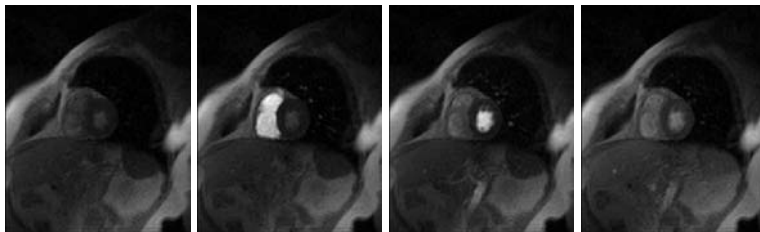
Example of four time points taken from a first-pass perfusion MRI acquisition. From left to right: before the bolus reaches the heart, bolus in the right ventricle, bolus in the left ventricle and diffusion in the myocardial wall.
